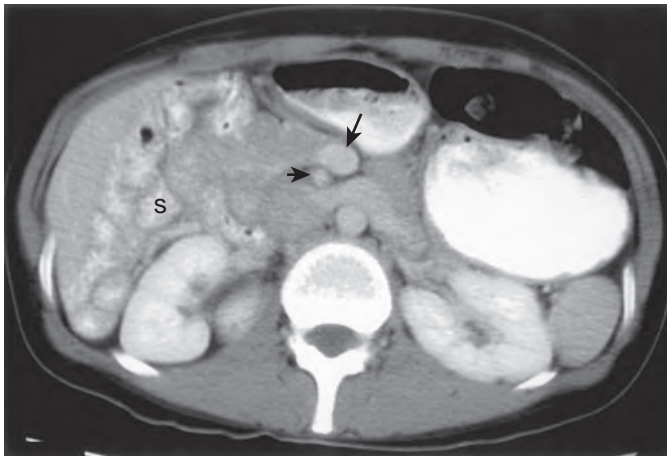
Intestinal malrotation. Axial CT through the tip of the liver shows that the superior mesenteric vein (*long arrow*) lies anterior and to the left of the superior mesenteric artery (*short arrow*). The jejunum (s) lies in the right upper quadrant.
